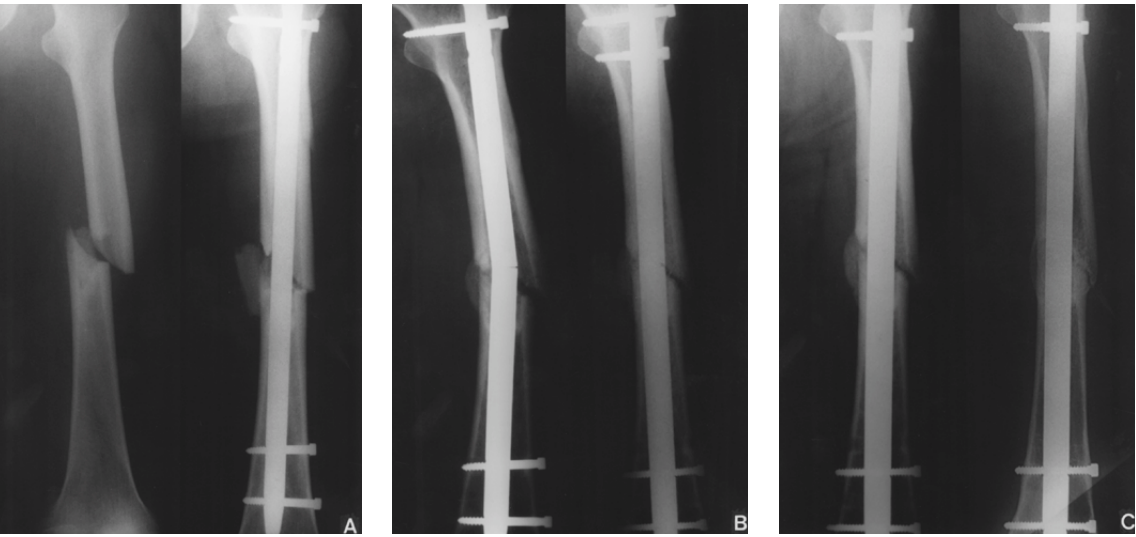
The preoperative roentgenogram of 58-year-old man shows Winguist-Hansen type II femoral shaft fracture (Lt), and the postoperative roentgenogram shows medial fracture gap with displaced fracture fragment(Rt).
